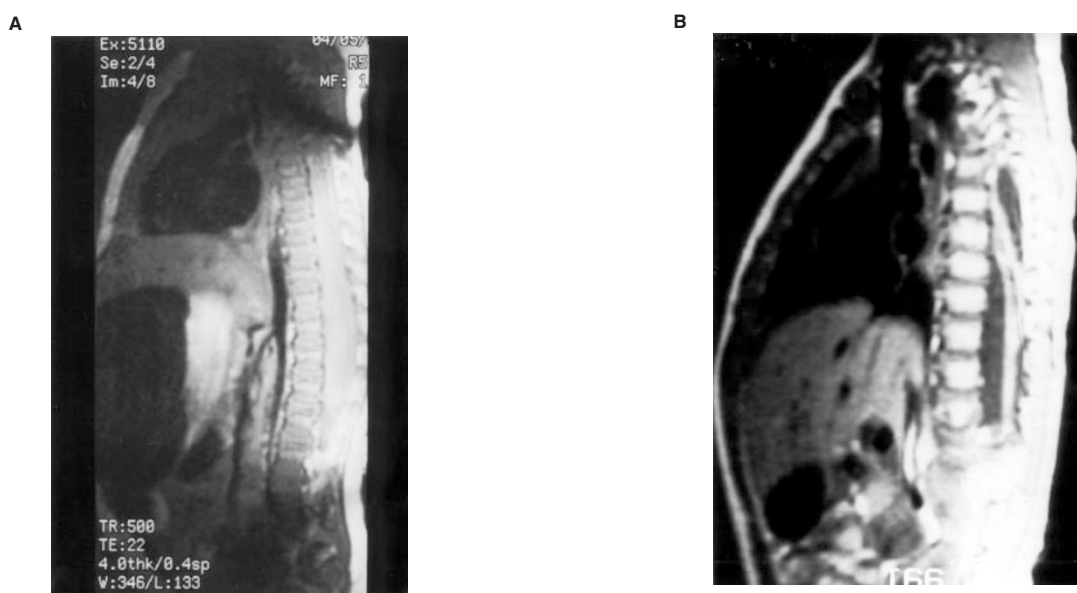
Response to BB SFOP chemotherapy in a 3-month-old girl with a holocord tumour. This 3-month-old baby presented with quadriplegia, the Claude Bernard Horner sign and stiff neck. MRI showed a holocord tumour from C2 to L5 with no evidence of leptomeningeal spread (A). After the first cycle, her clinical condition improved dramatically, in parallel with radiological signs. At the end of BB SFOP chemotherapy she remained paraplegic without significant bladder dysfunction, and MRI showed a complete response (B)
